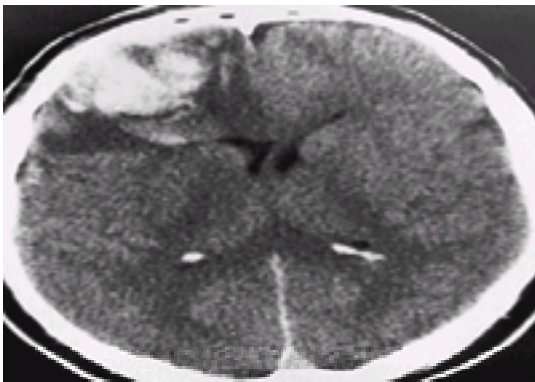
Intraparenchymal hemorrhage. This adolescent was an unrestrained passenger in a high-speed motor vehicle collision. He was comatose on presentation. A head computed tomography (CT) scan shows a large area of intraparenchymal hemorrhage in the right frontal region. Note also, the surrounding area of low-density cerebral contusion.
